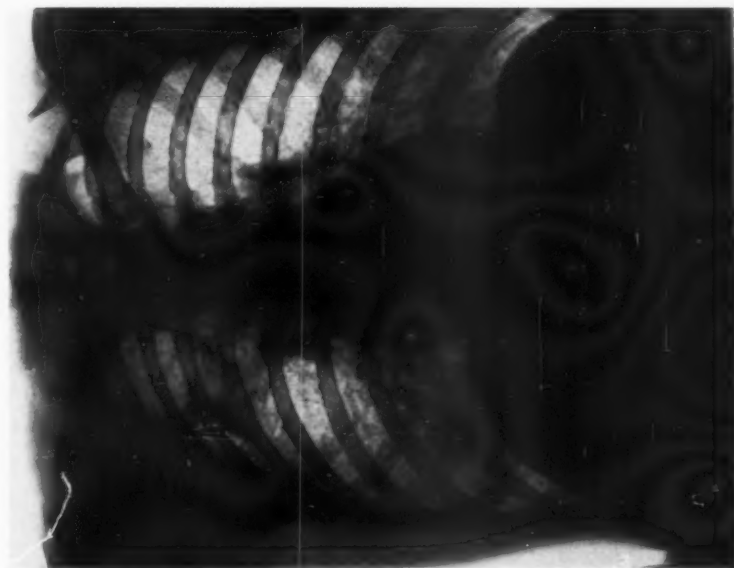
An ordinary radiograph.
